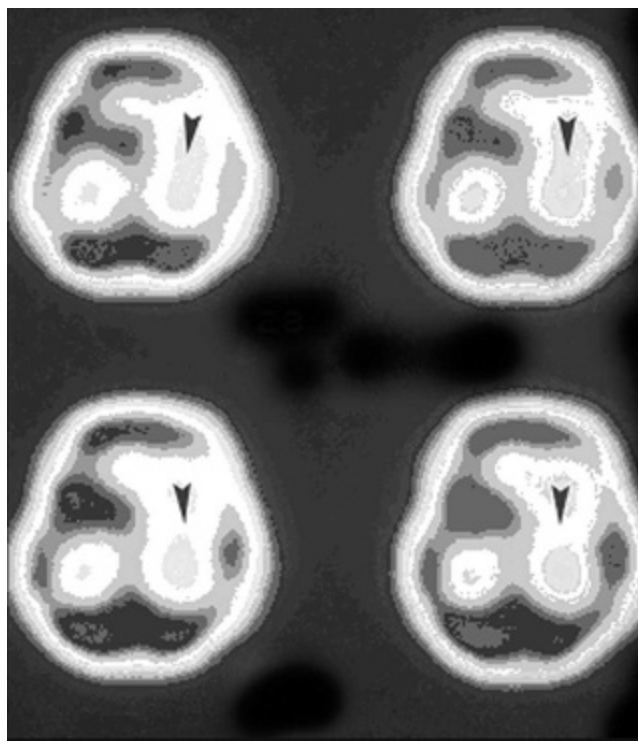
Transaxial slices of the <sup>99m</sup>Tc-HMPAO brain single-photon emission computed tomography shows hypoperfusion on the left basal ganglia in a 7.5-year-old girl with Down syndrome (arrowheads indicate hypoperfusion regions).
